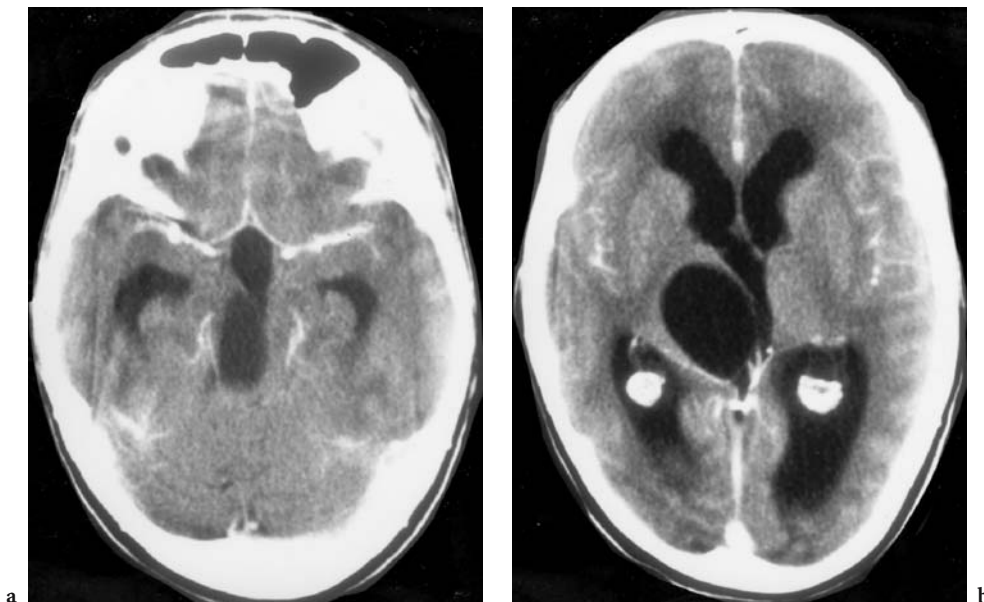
A 36-year-old woman with double vision in all directions, except the left, persisting for several weeks. The patient underwent emergency examination for acute loss of consciousness and bilateral papilledema. Diagnosis: intraparenchymal arachnoid cyst of unknown origin in the right thalamus and superior quadrigeminal plate causing an acute occlusive hydrocephalus. Axial contrast-enhanced CT: at the level of the quadrigeminal plate (a) and Monro's foramen (b), demonstrating isodensity of the CSF and the cystic content. The cyst extends to the thalamus, depressing the aqueduct (leading indirectly to a blockade of the left foramen of Monro, with asymmetrical widening of the posterior horn of the left ventricle) and dislocating the partially dilated third ventricle
